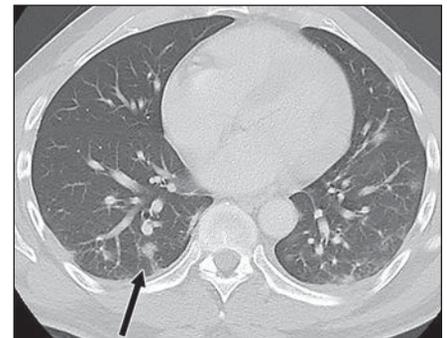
50-year-old man with epigastric and flank pain and diarrhea. Axial CT of abdomen and pelvis shows bilateral peripheral and basilar-predominant ground-glass and nodular opacities (*arrow*), suggestive of coronavirus disease (COVID-19).
